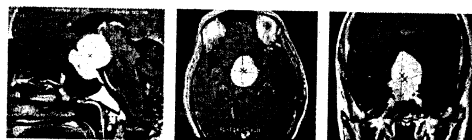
MRI showing tumour in the middle cranial fossa (Pituitary macroadenoma)
